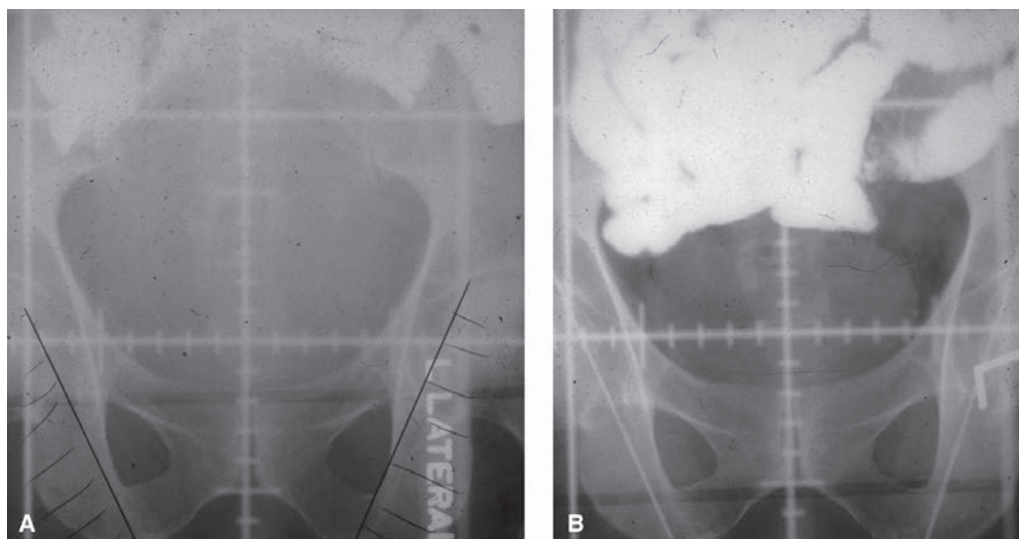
A and B: Anterior–posterior radiographs with and without bladder distention in a patient with contrast in small intestine.
